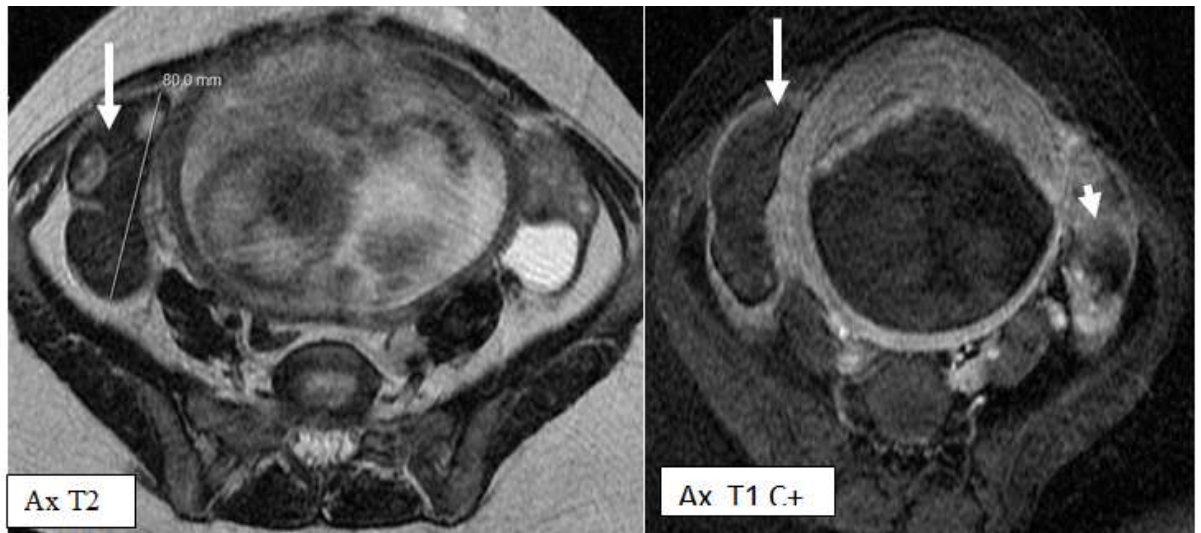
Pelvic MRI of a 23 WA pregnant woman showing an enlarged right ovary, not enhanced after contrast, measuring 8 x 4 cm, unlike the left ovary which is normally enhanced (arrowhead).
